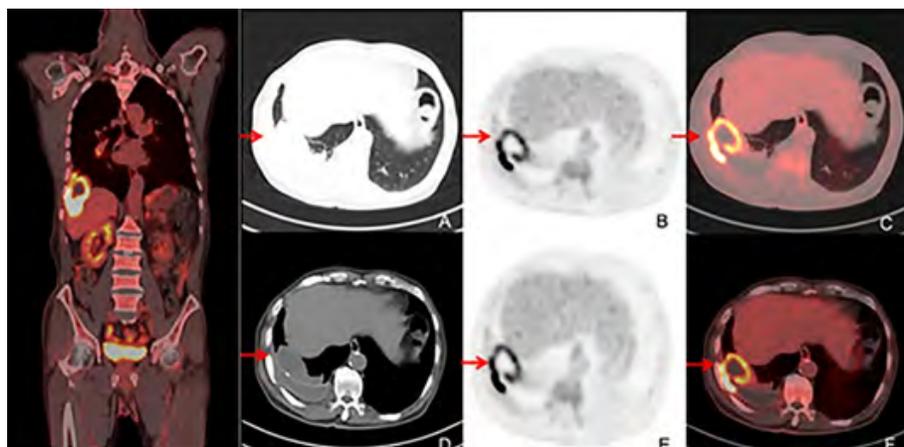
Examination of 18F-FDG PET/CT.
